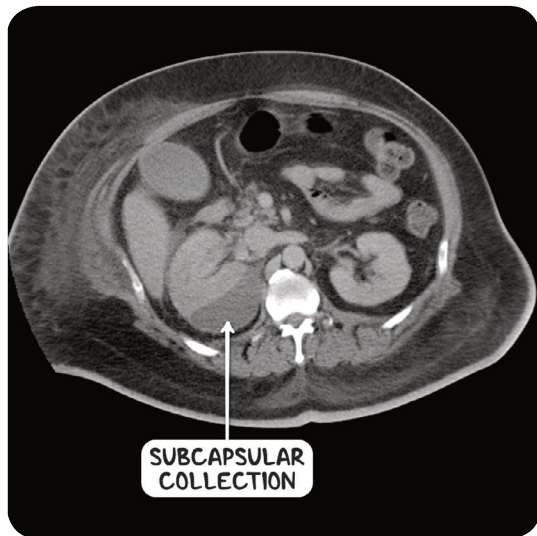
A CT scan of the abdomen in the axial plane demonstrating a subcapsular abscess secondary to pyelonephritis of the right kidney.
